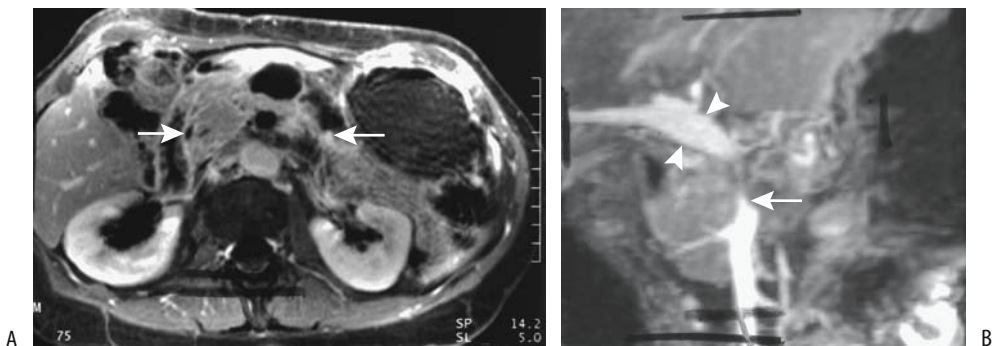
Mucinous cystic adenocarcinoma. A: A contrast-enhanced MRI reveals a tumor containing solid and cystic components (arrows). B: Magnetic resonance angiography (MRA) identifies a narrowed superior mesenteric vein (arrow), patent portal vein (arrowheads) and nonvisualization of an occluded splenic vein. (Source: From Burgener FA, Meyers SP, Tan RK, Zaunbauer W. *Differential Diagnosis in Magnetic Resonance Imaging*. Stuttgart: Thieme, 2002, with permission.)
